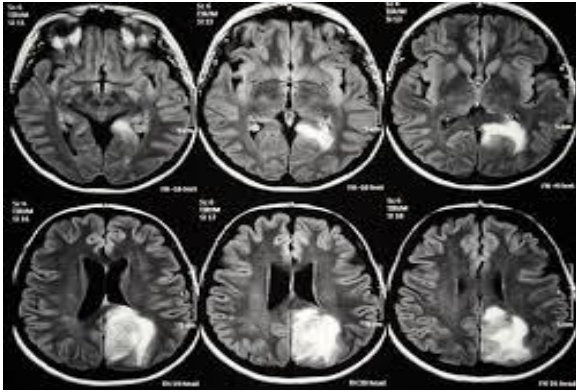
Examples of MRI brain tumor images.
